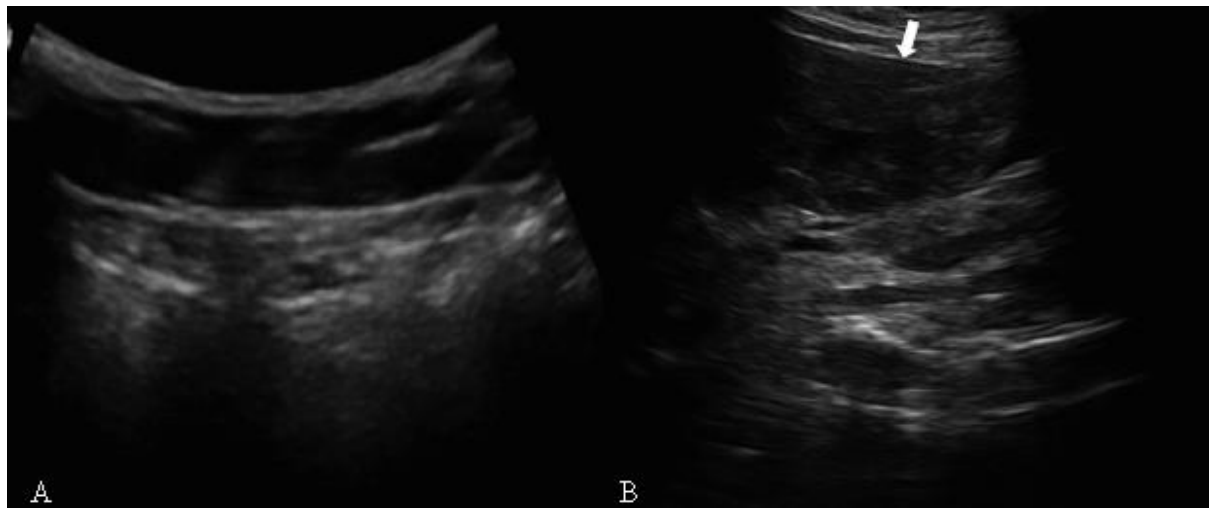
Ultrasound images of the left lobe of the liver taken from Genelyn embalmed cadavers with A before and B after embalming.
